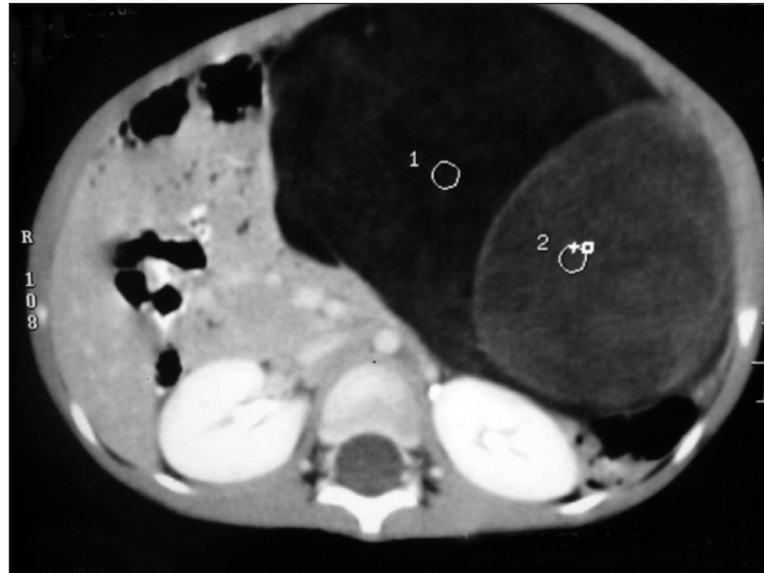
Contrast-enhanced computed tomography showing a huge heterogeneous mass occupying left abdomen; anteromedial to colon and shift of whole of small bowel to the right side.
